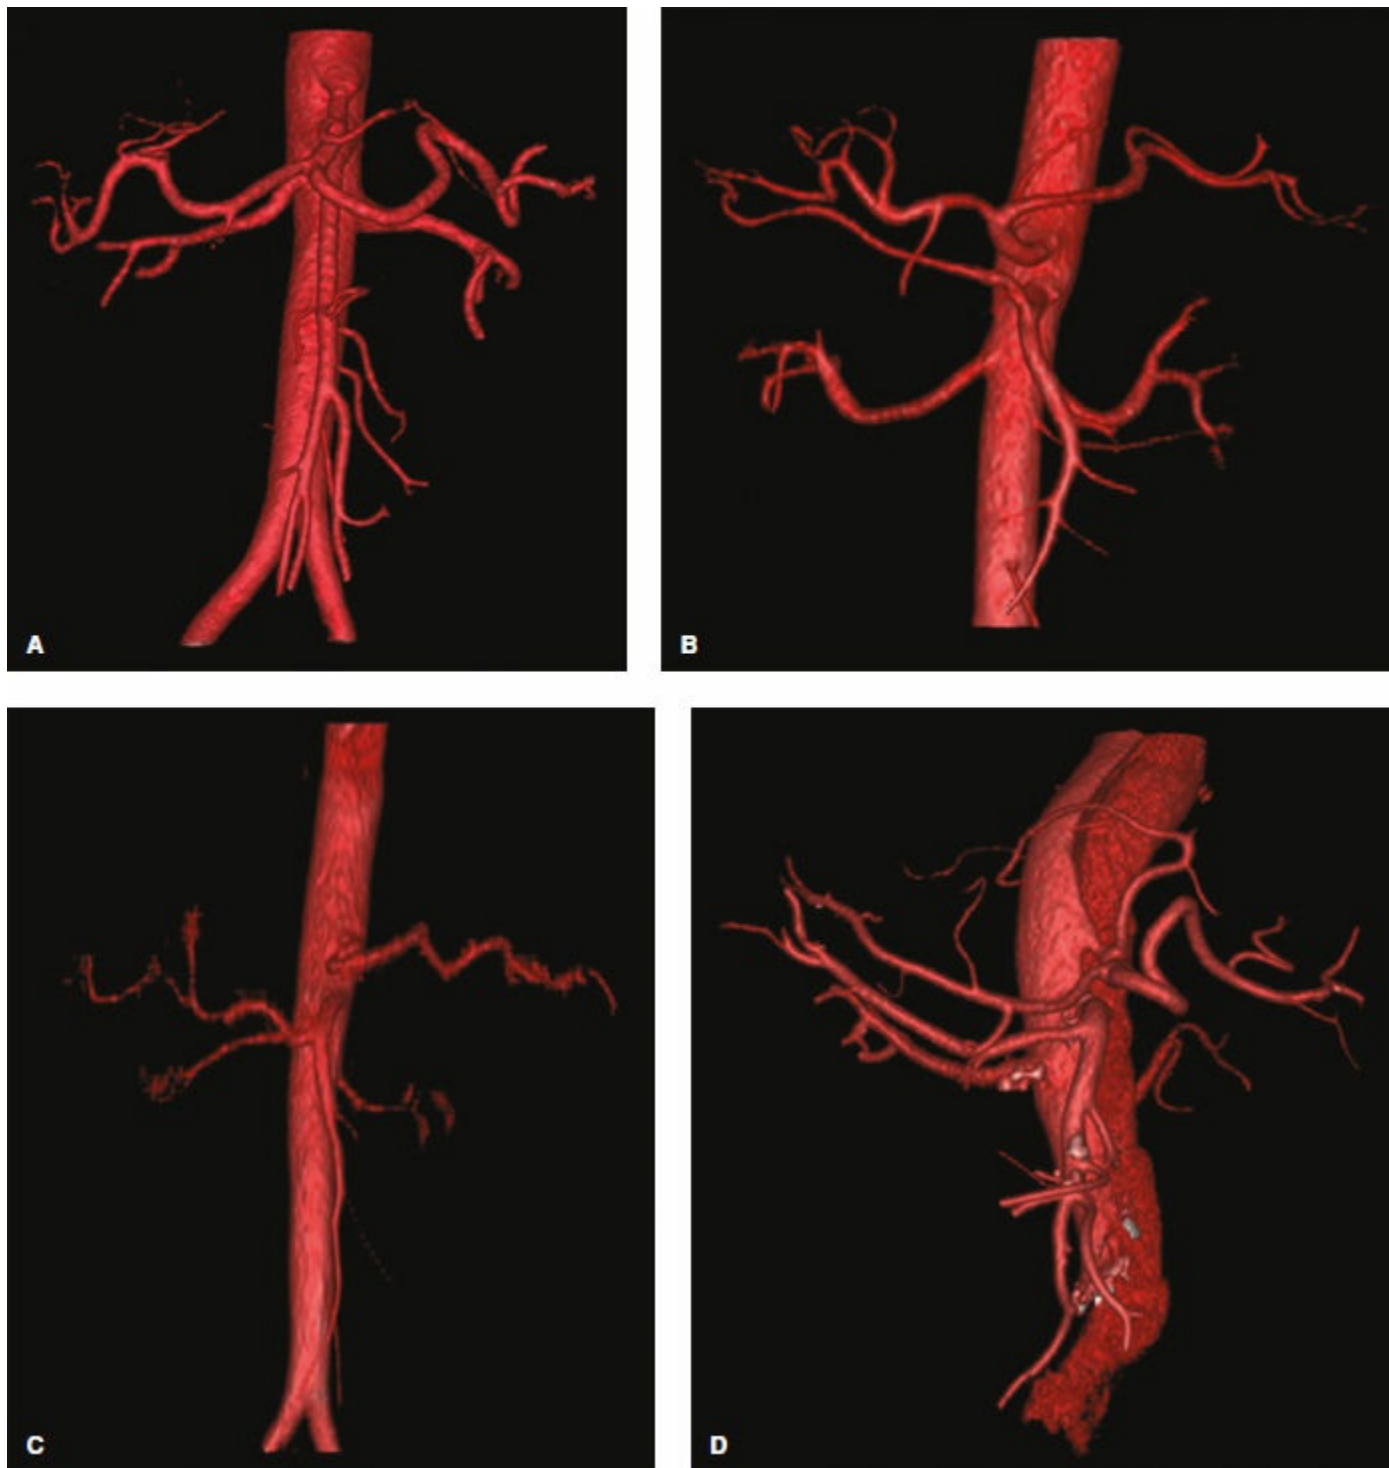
3D CT reconstructions of (A) Normal arterial supply to the pancreas, (B) Replaced right hepatic artery arising from the superior mesenteric artery, (C) Replaced common hepatic artery arising from the superior mesenteric artery and (D) Replaced left hepatic artery arising from the splenic artery.
